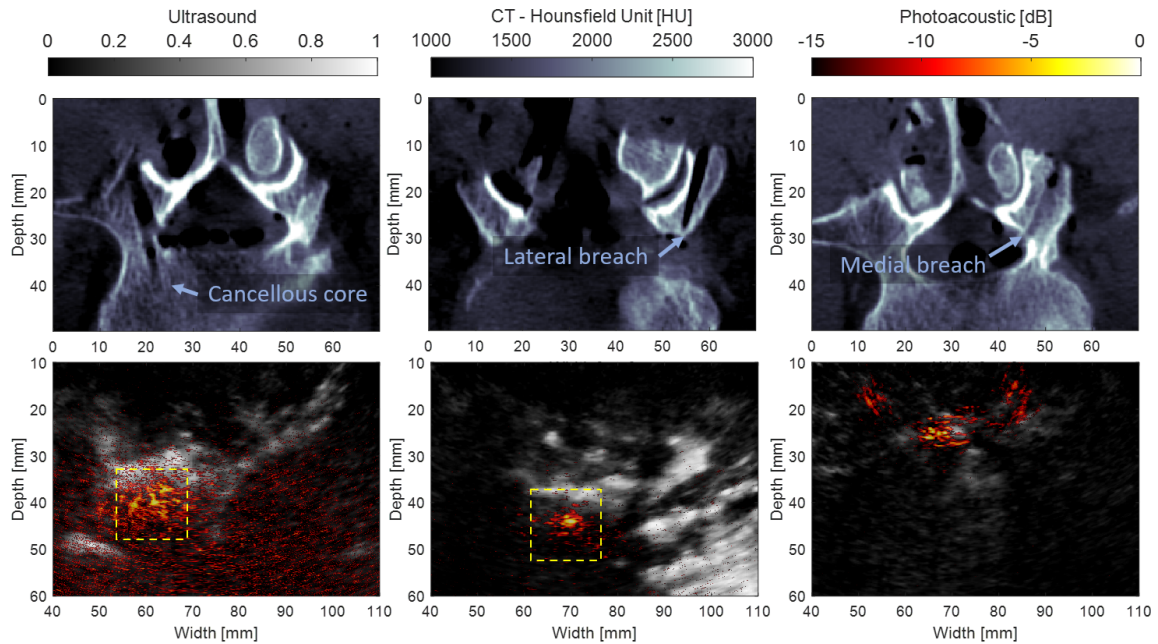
CT axial slice (top) and corresponding LW-SLSC ultrasound images co-registered with DAS photoacoustic image (bottom). The photoacoustic images represent example signals obtained when the tip of the optical fiber touches the bottom of the cancellous core, the cortical bone of a lateral breach, and the cortical bone of a medial breach, from left to right, respectively. The yellow boxes indicate regions of interest for Fig. 3-3.
